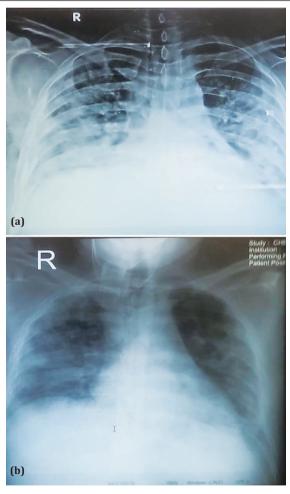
Chest x-ray PA view of a patient showing improvement after tocilizumab administration.
